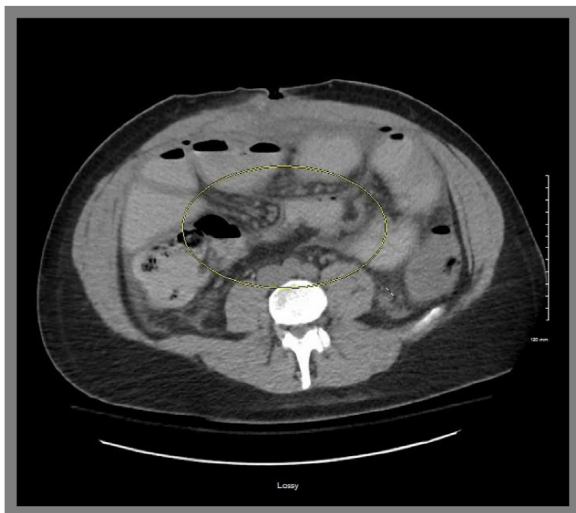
CT on POD 3 showing a possible transition point in the distal ileum, approx. 6 cm from the cecum.
